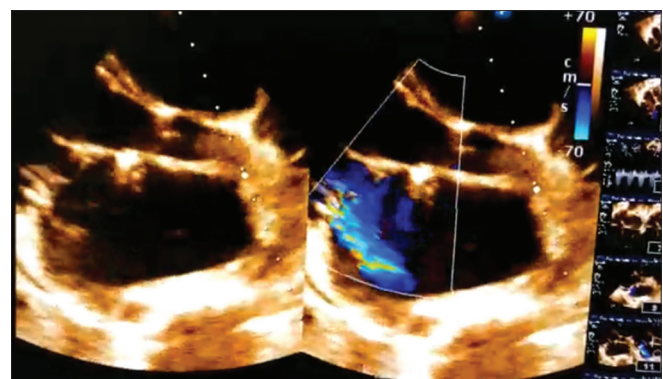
Still image of parasternal long-axis view showing mitral inlet
